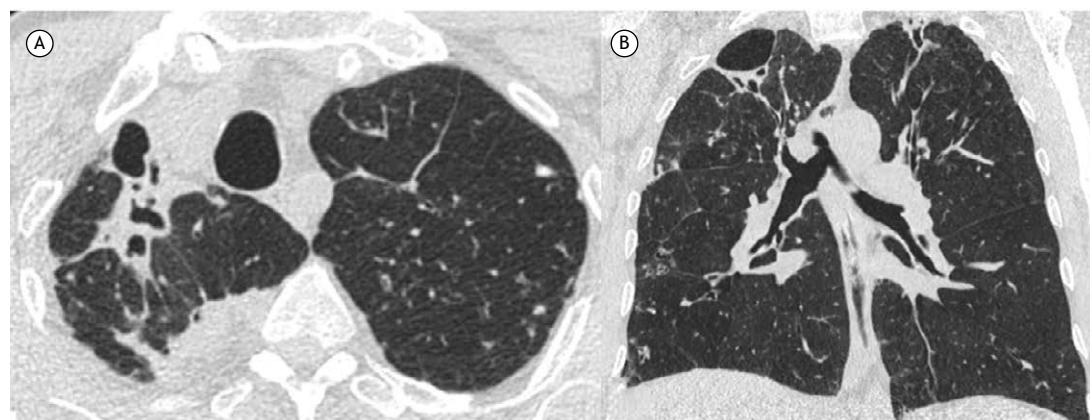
Axial (A) and coronal (B) CT scans with lung window settings revealing distortion of the lung parenchyma in the upper lobes, accompanied by right apical fibrosis, emphysematous bulla, and cylindrical bronchiectasis.
